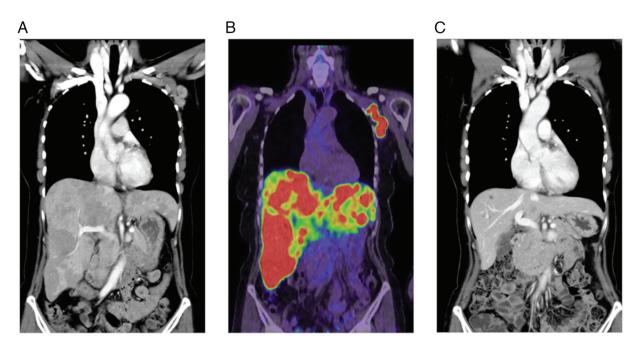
Multiple metastases in the liver and left axillary lymph nodes. (A) Contrast-enhanced CT indicated multiple low-density masses in both lobes of the liver and left axillary lymph nodes. (B) Fluorodeoxyglucose positron emission tomography revealed abnormal uptake in the liver and left axillary lymph nodes. (C) At 6 months after chemotherapy induction, CT images demonstrated a complete response of the hepatic and left axillary lesions. CT, computed tomography.
